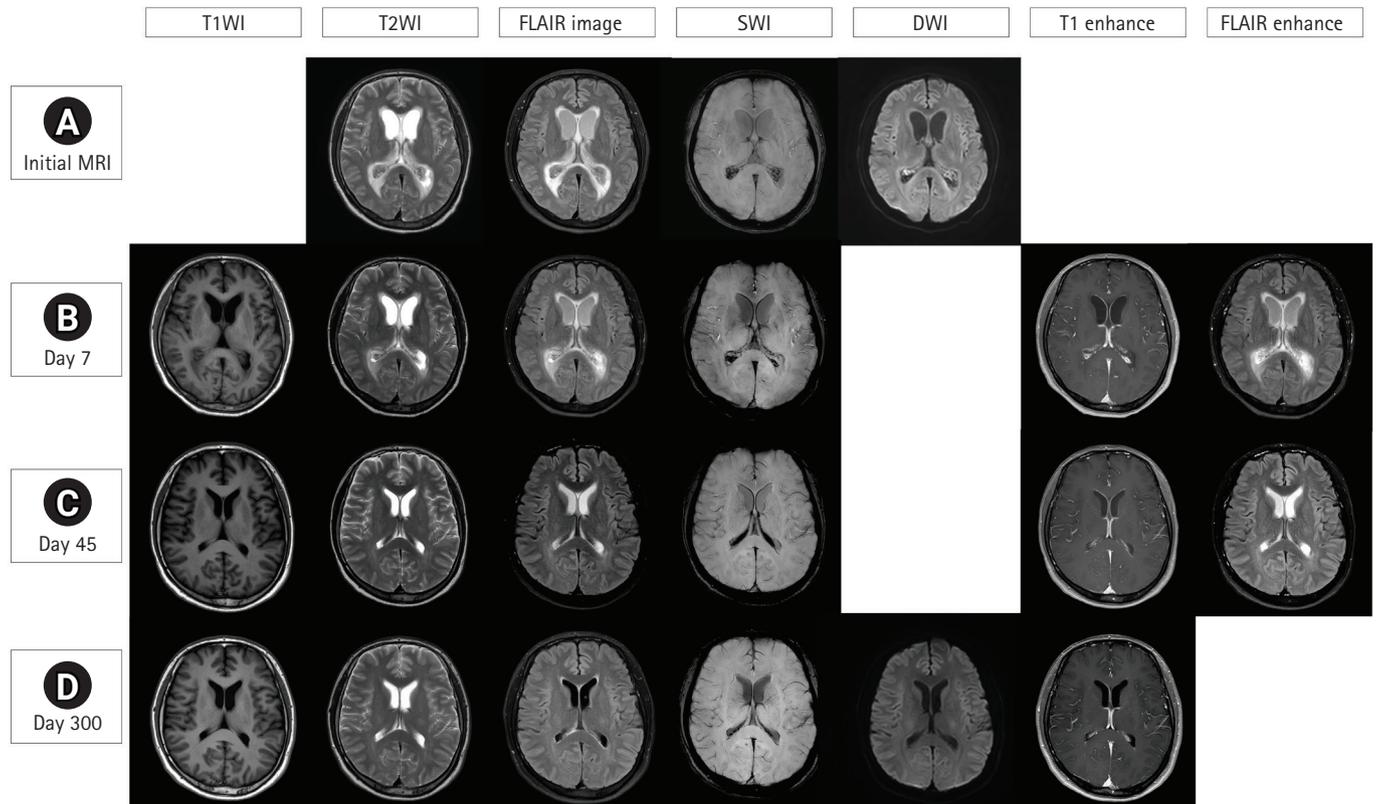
Serial brain magnetic resonance imaging (MRI) findings of invasive streptococcal sepsis with ventriculitis and choroid plexitis. Initial brain images reveal hydrocephalus with severe interstitial edema and non-suppressed high-signal fluid in the lateral ventricle on fluid-attenuated inversion recovery (FLAIR) imaging, suggesting pyogenic ventriculitis. In addition, restricted diffusion on diffusion-weighted imaging (DWI) and low signal intensity on susceptibility-weighted imaging (SWI) in both choroid plexuses indicate choroid plexitis with hemorrhaging (A). Although the patient's mental status improved after administration of intravenous vancomycin and ceftriaxone, no significant change is observed in the brain MRI on day 7 after admission (B). The brain MRI of day 45 shows improved hydrocephalus, interstitial edema, ventriculitis, and choroid plexitis; however, a high signal of cerebrospinal fluid on FLAIR imaging is noted (C). Finally, on day 300, a normal brain MRI is observed (D).
